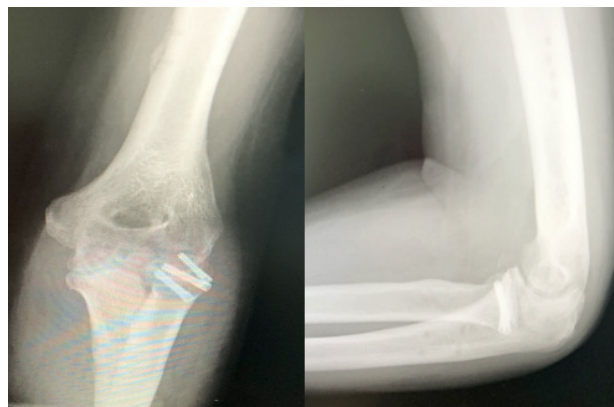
Radiographic study performed one year and a half after the fracture-dislocation showed a satisfactory result: anteroposterior view (left); lateral radiograph (right).
